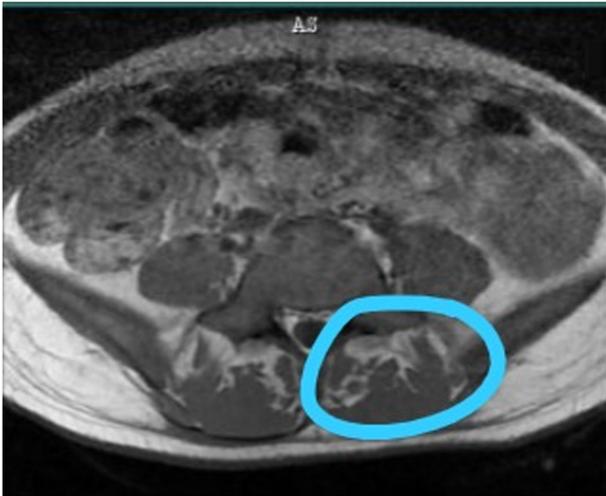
MRI demonstrating mild straightening of the spine and fatty atrophy in back muscles (blue circle), indicating reduced mobility.
